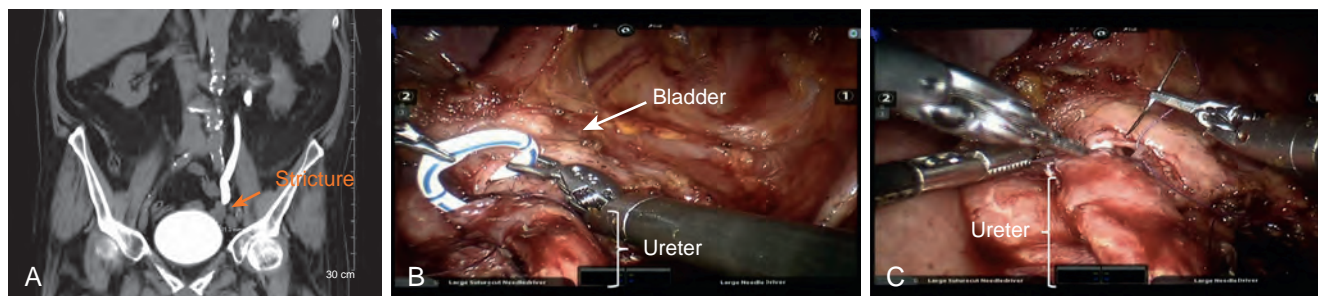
Intraoperative photograph of a patient undergoing a robotic right ureteral neocystostomy for distal ureteral stricture seen in CT urography (A). B, The distal coil of the ureteral stent being placed through the opening in the bladder after completion of half the ureteral anastomosis. C, Completing the ureteral anastomosis.
